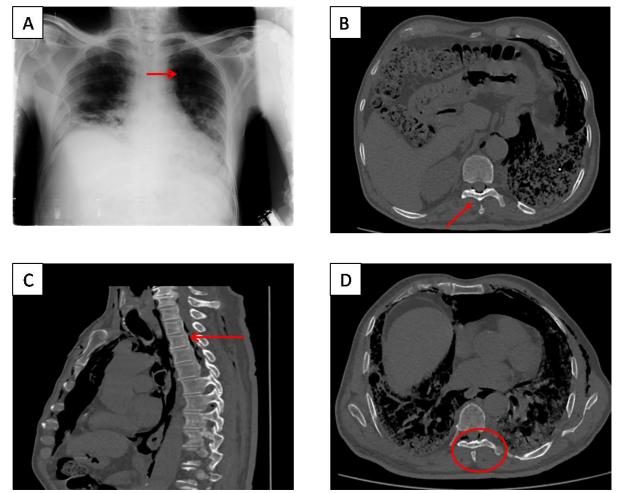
A:- Chest X-Ray B:- Non contrast CT chest -Axial section of upper abdomen, C:- Non contrast CT chest -lower thorax D:- Non contrast CT chest Coronal section
